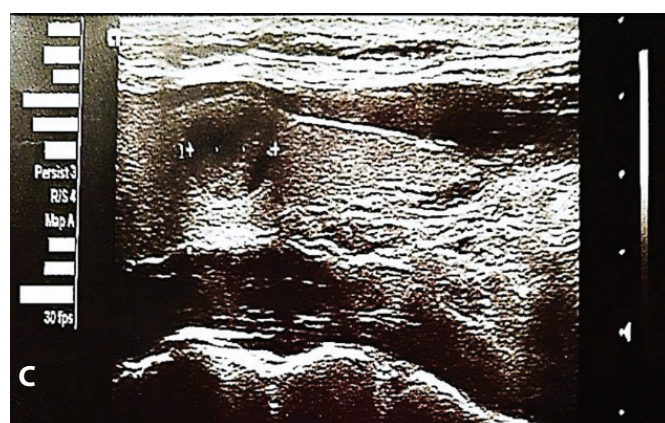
Ultrasound imaging of the patient's thyroid gland. Ultrasound examination of the thyroid gland detected a suspicious nodule in the left lobe. A. and B. Small hypoechoic, solid nodule (5mm) with echogenic foci, vascularization and irregular margins (TIRADS4, score 6) in the mid portion of the left thyroid lobe. C. In the contralateral right lobe, anterior and cranial, there was a mixed, predominantly cystic nodule measuring 9 mm with central vascularization. Unlike the left nodule, this lesion displayed a different imaging pattern and lacked suspicious malignant features
